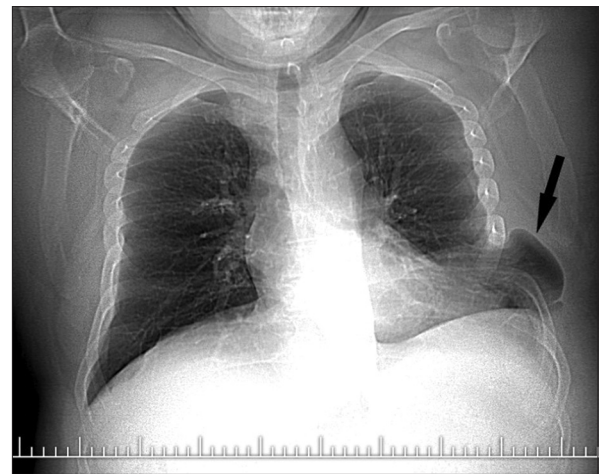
Initial chest radiograph: Presentation of lung herniation through sixth intercostal space (herniated lung is pointed by an arrow)
